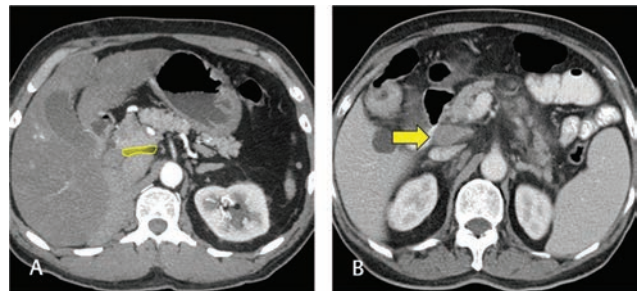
Station 13. Axial CT (A) in arterial phase depicts the station 13 location, the retropancreatic nodes, on posterior surface of pancreatic head cranial to duodenal papilla (yellow area in A). Axial CT (B) in venous phase shows an enlarged station 13 node, sometimes also referred to as posterosuperior pancreaticoduodenal node. If surgery is planned, it requires kocherization of duodenum for its resection. CT, computed tomography.
